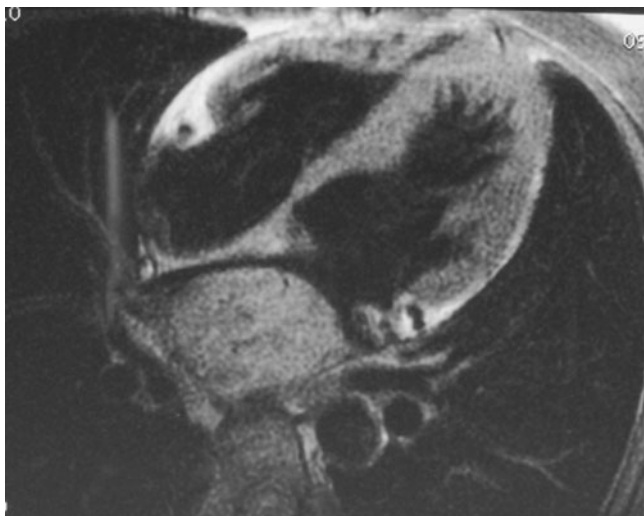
MRI of left atrial paraganglioma.
